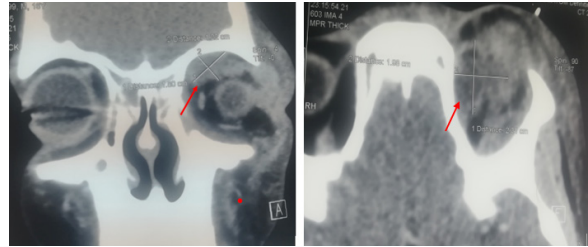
Orbital CT scan showing left orbital cellulitis complicated by an orbital abscess (arrow)
